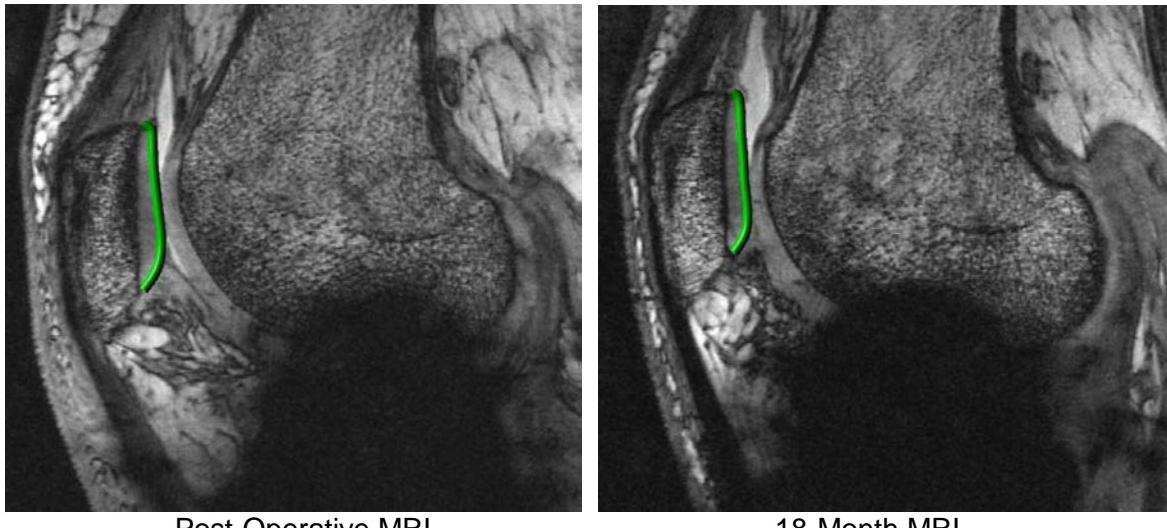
Sagittal view of PTA002 MRI scans. Green outline indicates articular cartilage surface of the patella in both images.
